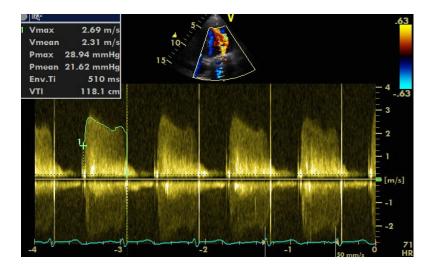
Transesophageal echocardiography of mitral valve showed mean gradient of 21.62 mmHg
